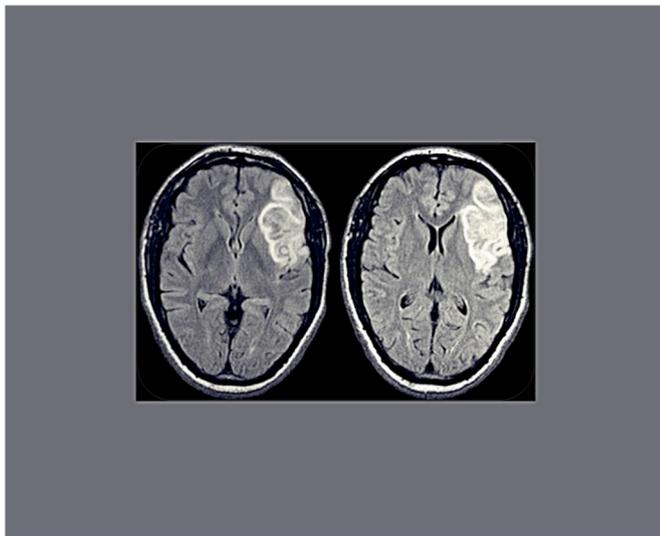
Case 4 MRI Flair demonstrates a left frontotemporal lesion consistent with evolving edema.
